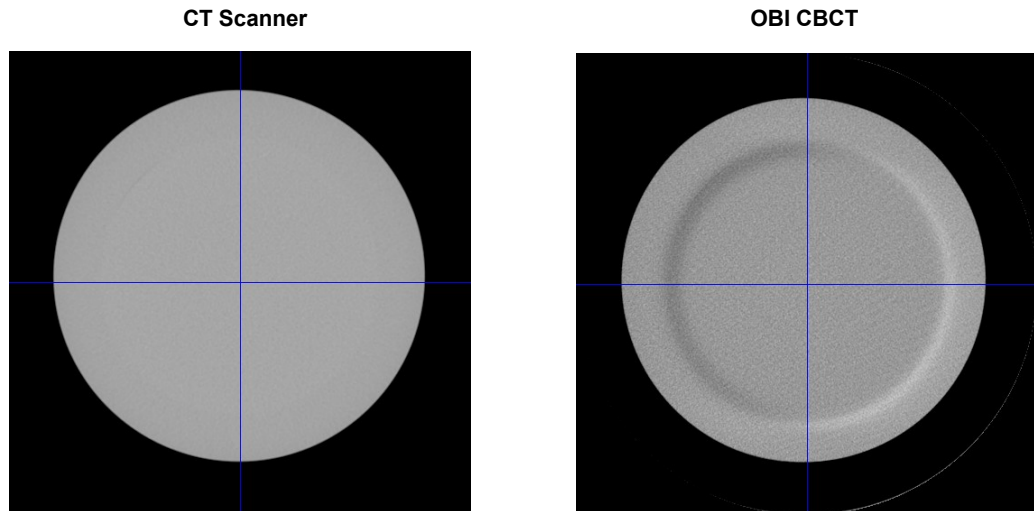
Catphan 504 Uniformity module images acquired using a conventional CT scanner and OBI CBCT.
